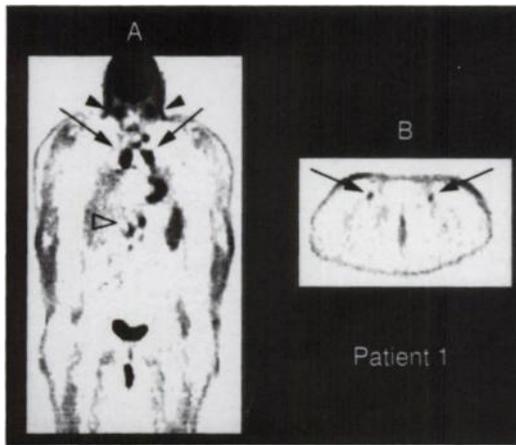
Whole-body ^{18}F FDG scan of Patient One: (A) Coronal slice through the lung hilum showing intense ^{18}F FDG uptake by hilar lymph nodes (arrow), cervical lymph nodes (arrow head) and paraaortic nodes (open arrowhead). Increased splenic uptake is also seen. (B) Transaxial slice through the groin shows uptake in inguinal lymph nodes.
